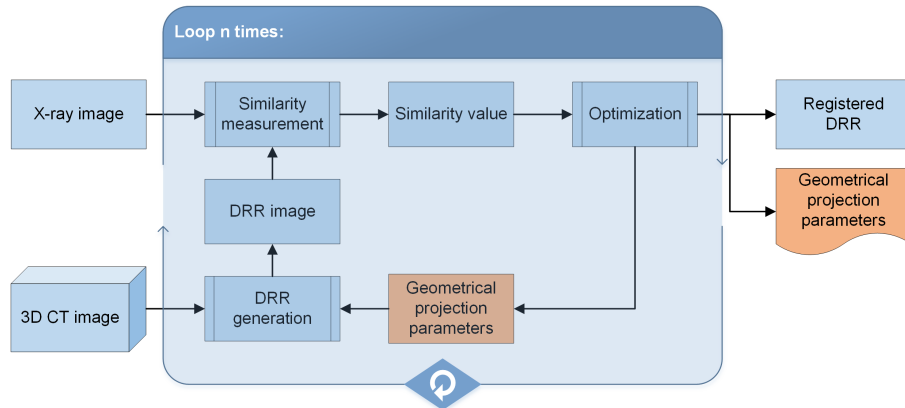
Iterative 2D-3D intensity-based registration. The approach aims to determine the C-arm pose (geometrical projection parameters) by maximizing the similarity between the acquired X-ray image and created DRRs.
